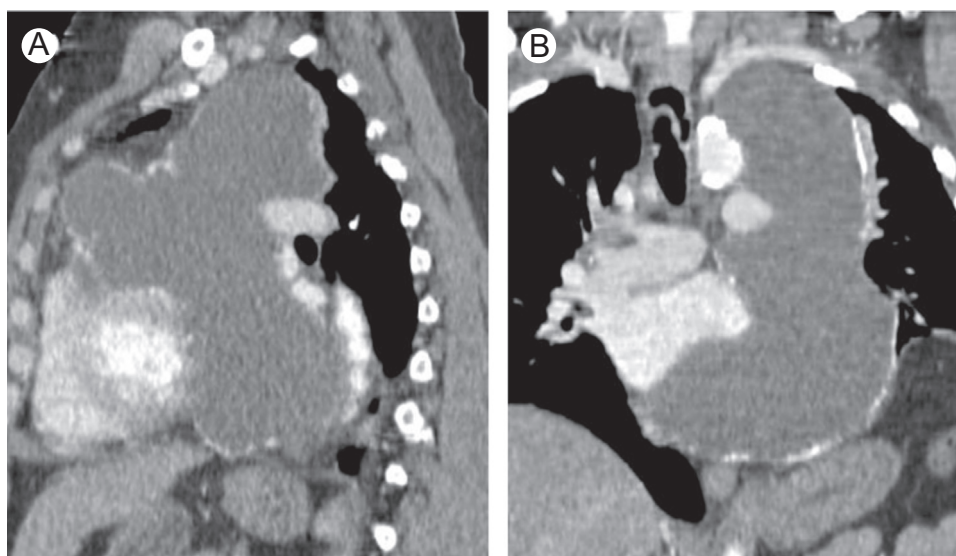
Large chronically inflamed pericardial cyst. Sagittal (A) and coronal (B) contrast-enhanced CT images of the chest demonstrating a large, peripherally calcified fluid-attenuation mediastinal mass displacing vascular structures. Upon surgical resection, pathologic analysis yielded acute on chronic inflammation of a large pericardial cyst.
